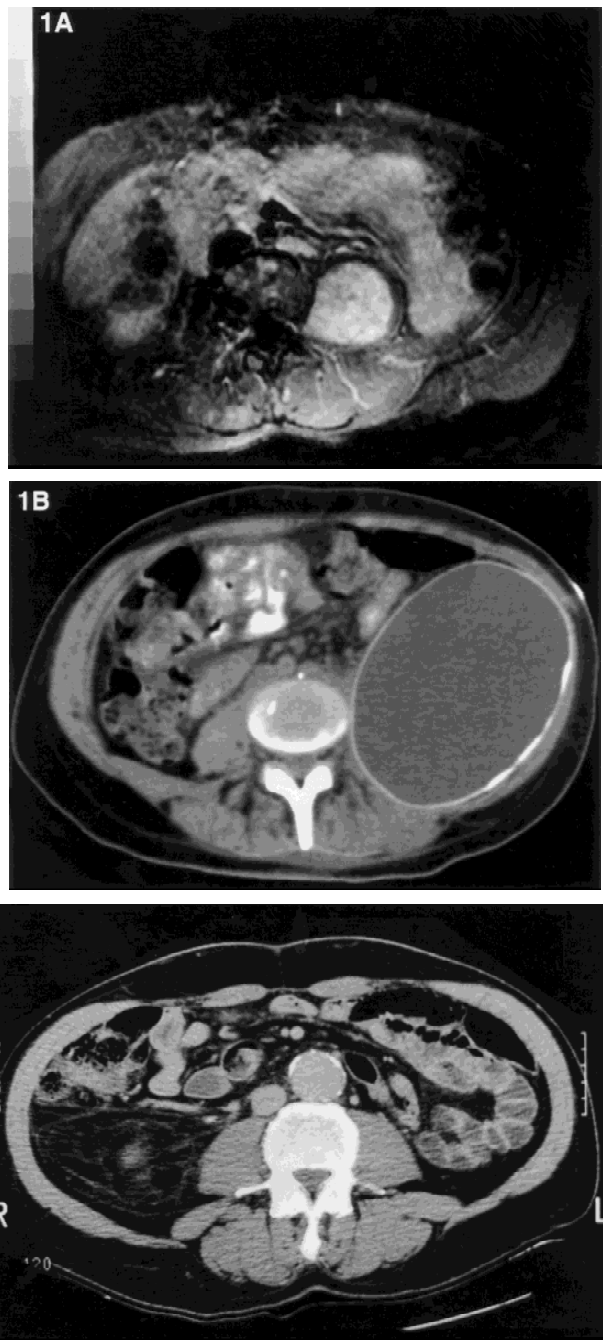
A. Preoperative MRI scan showing close proximity of bowel and psoas tumor (patient 1). B. CT scan after tumor resection showing displacement of previously adjacent bowel by implants (patient 1).
